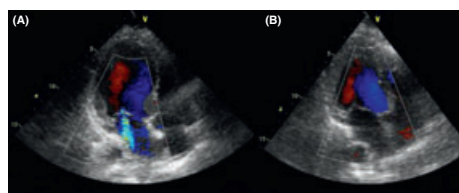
Apical four-chamber view by color Doppler echocardiogram. (A) Initial moderate mitral regurgitation. (B) The mitral regurgitation disappeared 1 day later.
